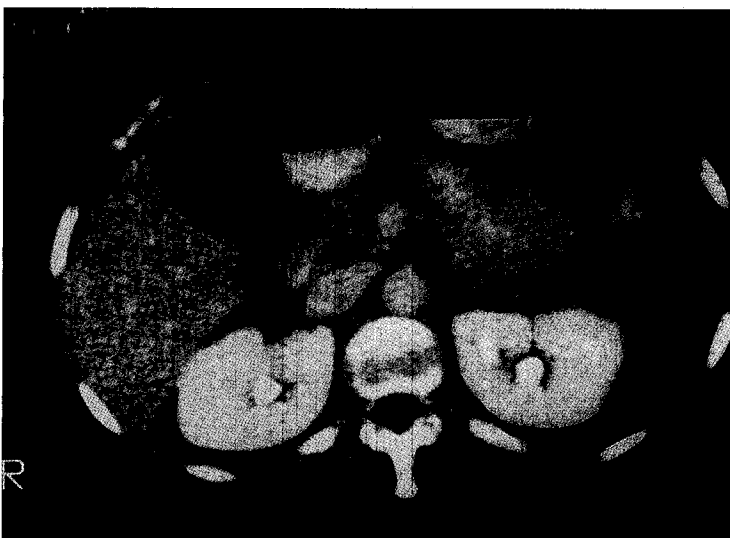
This CT scan of the abdomen demonstrates a large mass in the fundus of the gallbladder.
